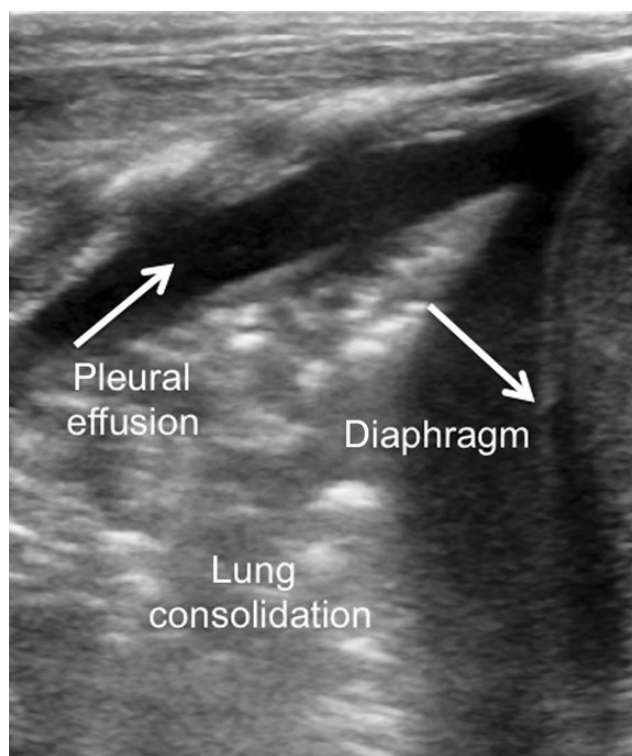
Sonographic appearance of pleural effusion and coexisting lung consolidation.
